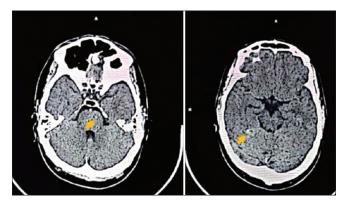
NCCT brain showing multiple calcified lesions. NCCT = noncontrast computed tomography
